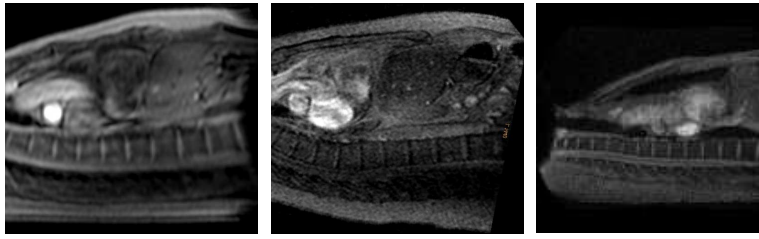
Spine images from MRI scans when patients are lying down supine.
